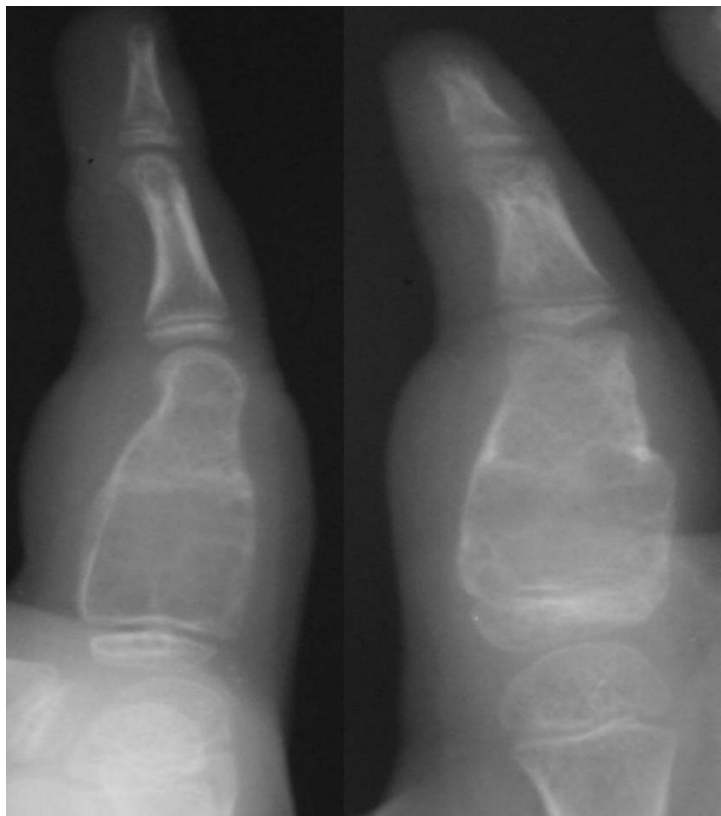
Preoperative radiograph of case 2 showing the lesion in proximal phalanx of index finger.
